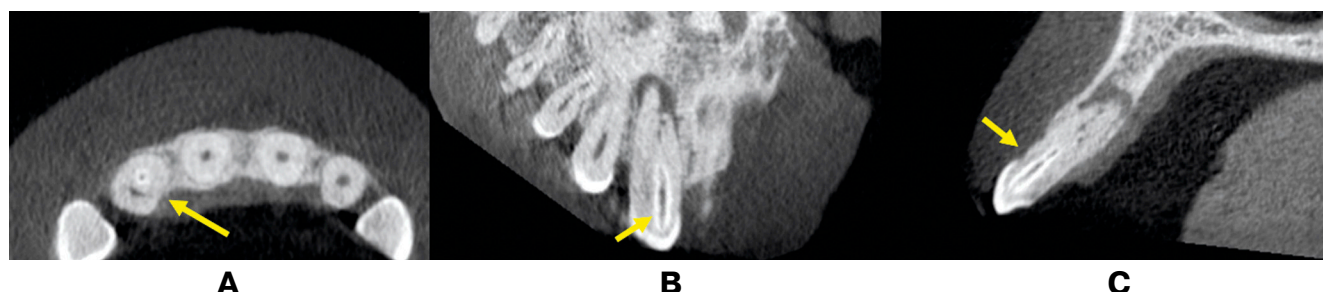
Cone beam computed tomography images showing Oehler's Type II dens invaginatus with palatogingival groove in right maxillary lateral incisor in (A) axial, (B) coronal and (C) sagittal sections
